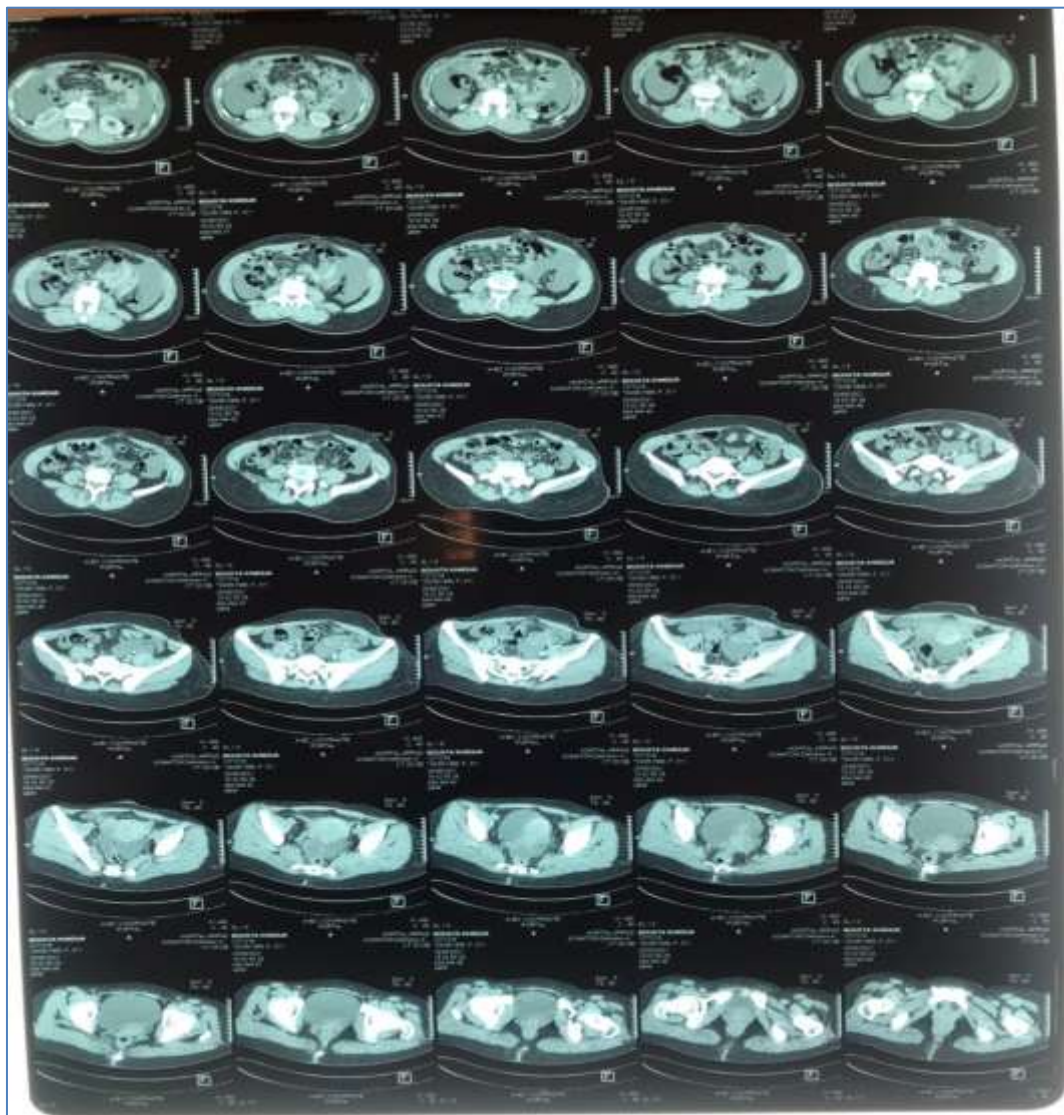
CT scan of the left ovary swollen in relation to the contralateral ovary, with two multipartitioned cystic formations (thin partitions), non-vascularized and without detectable endocystic vegetations and presence of a large peritoneal effusion
